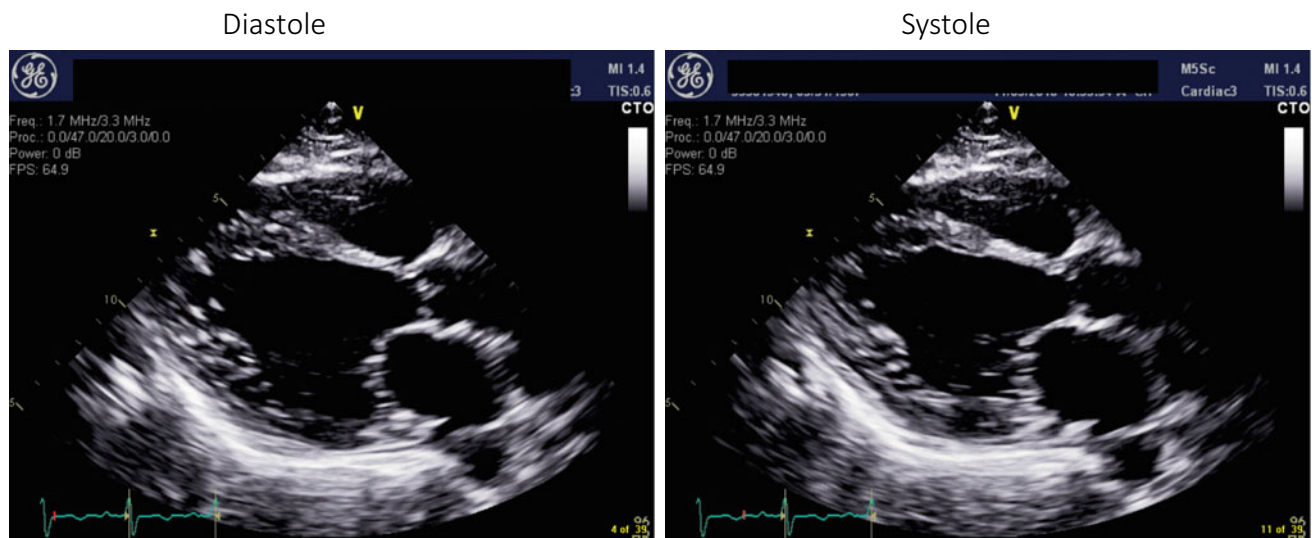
Transthoracic echocardiogram (TTE) on presentation with dyspnea on exercise showing severely reduced LV function with an ejection fraction of 17%, with grade III diastolic dysfunction
